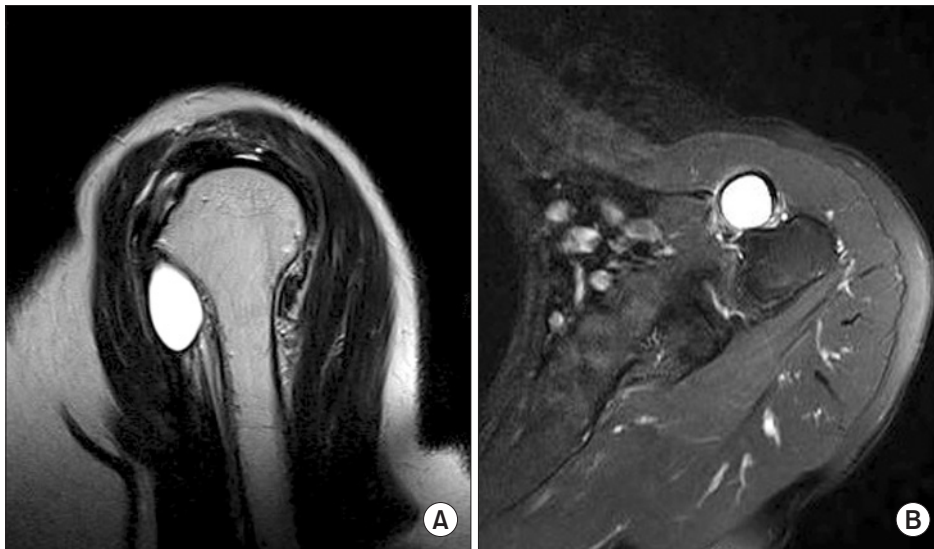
(A) The sagittal view of T2 weighted image of magnetic resonance imaging (MRI) shows oval cystic mass with high signal intensity, just distal to the greater tubercle. (B) The axial view of T2 weighted image of MRI shows thinning of the long head of biceps brachii tendon around the cystic mass.
